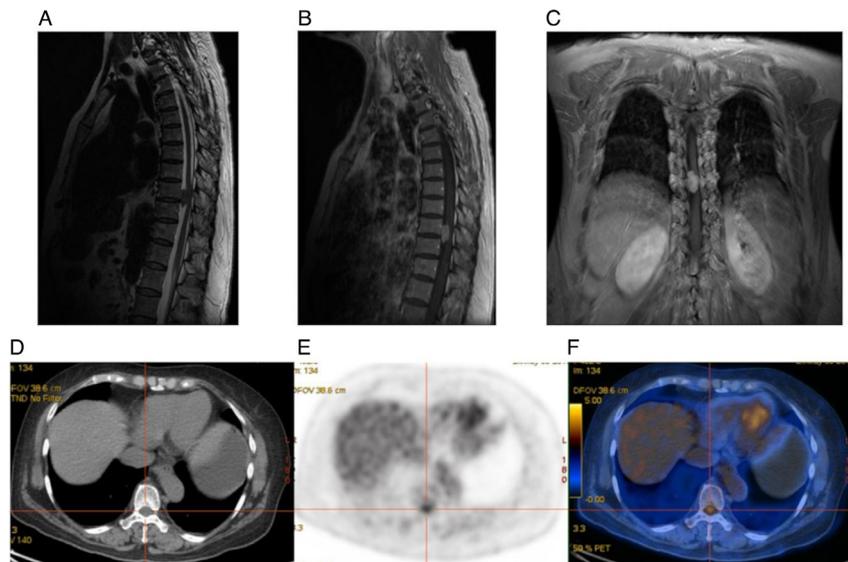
Female patient, 60 years of age, with numbness in both lower limbs and paresthesia. (A) Sagittal T2WI; (B) sagittal T1WI + C; (C) coronal T1WI + C showing a nodular T1 low T2 low signal shadow with clear borders in the extramedullary dura at the level of thoracic 9-10 vertebrae, with adjacent spinal cord compression, and significant enhancement with more uniform enhancement. (D) Transverse CT; (E) transverse PET; and (F) PET-CT fusion images showing slightly heterogeneous density within the thoracic 9-10 spinal canal, no significant enlargement, no destruction of adjacent bone, mildly increased FDG metabolism; maximum standardized uptake value, 3.71; peak standardized uptake value, 3.57; mean standardized uptake value, 2.46; metabolic tumor volume, 4.39; and total lesion glycolysis, 10.799. Meningioma was considered in the MRI and PET/CT, and the post-operative pathological diagnosis was schwannoma. PET, positron emission tomography; CT, computed tomography.
